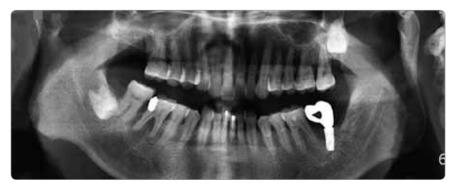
Delivery prosthesis radiography
